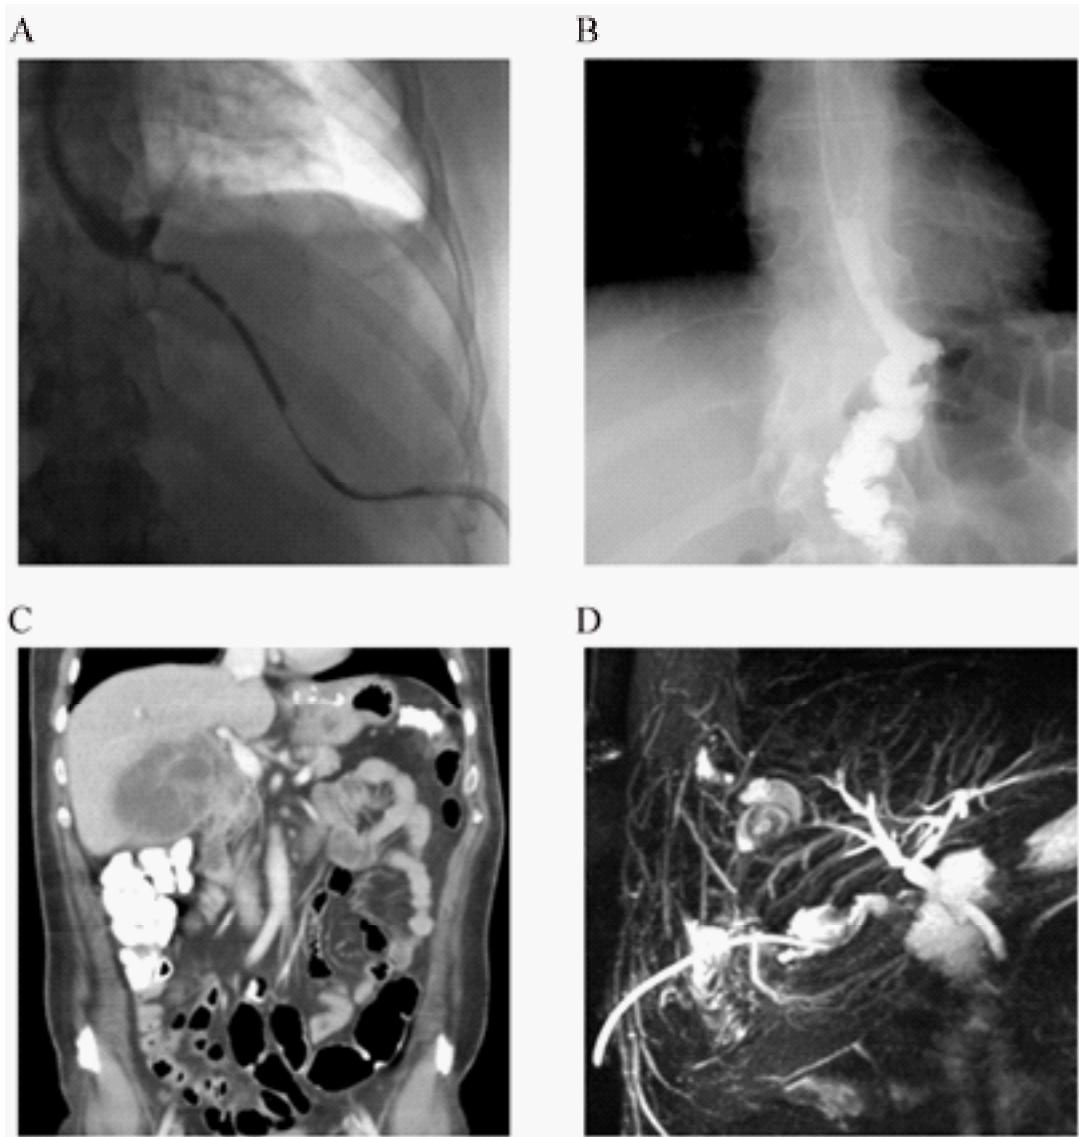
Radiological investigations. A: Water soluble swallow pre- recanalization showing contrast selectively opacifying the drain; B: Swallow test after the operation shows contrast passing the esophago-jejunal end to end anastomosis; C: CT abdomen showing the large gallbladder empyema six months after recanalization; D: MRCP after transhepatic cholecystectomy, with resolved empyema and normal biliary tree.
